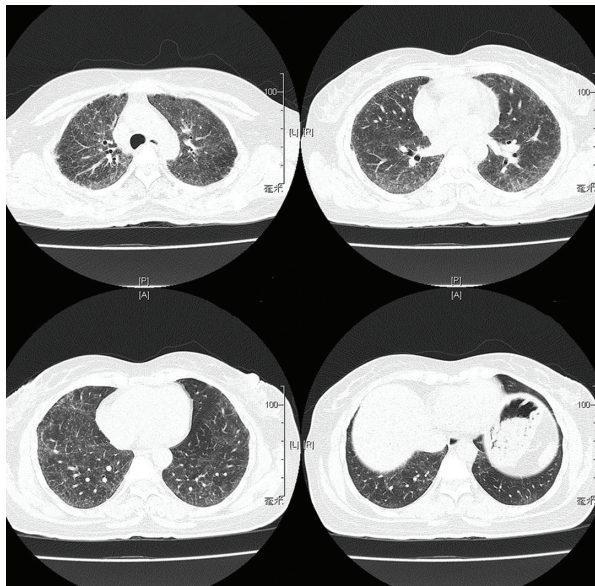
HRCT showing diffuse and symmetric ground-glass opacities and interstitial infiltrations in bilateral lungs.
